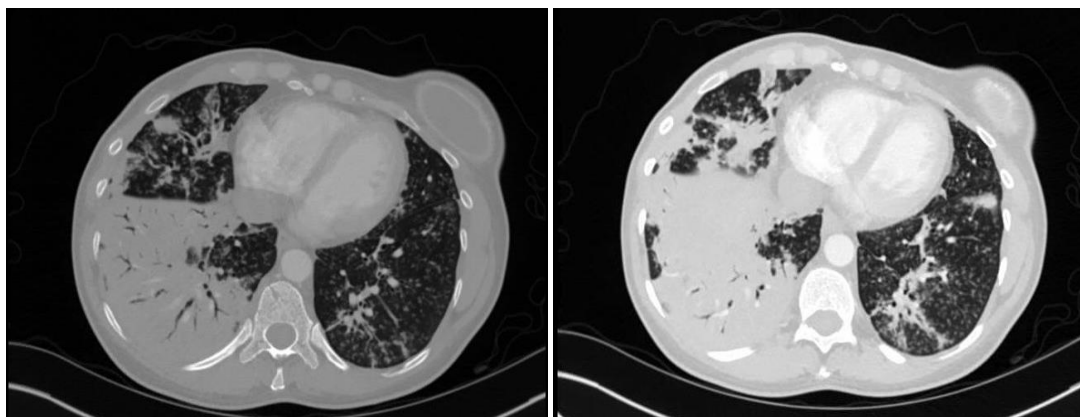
CT scan of the chest, axial view, with tree in bud opacities, bilateral opacities, and hilar lymphadenopathy.
